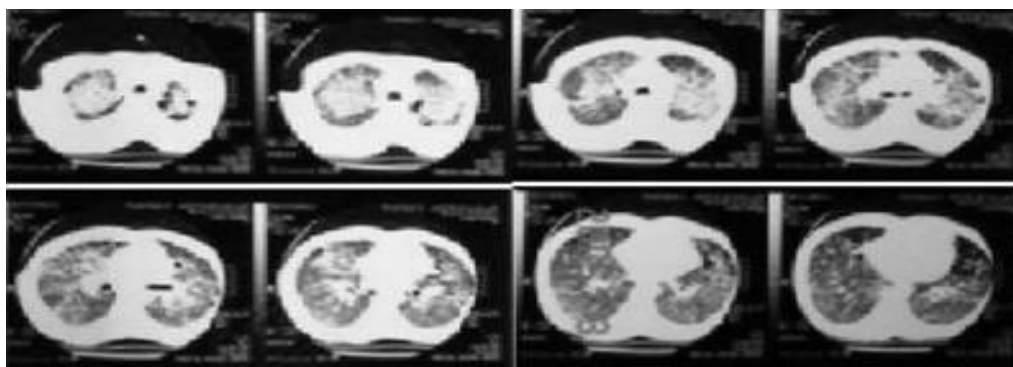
Chest high resolution computed tomography of the case.
